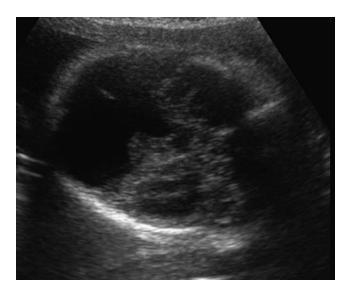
Transaxial sonogram of a fetal head demonstrating a posterior fossa cyst with cleft of the cerebellar vermis.
